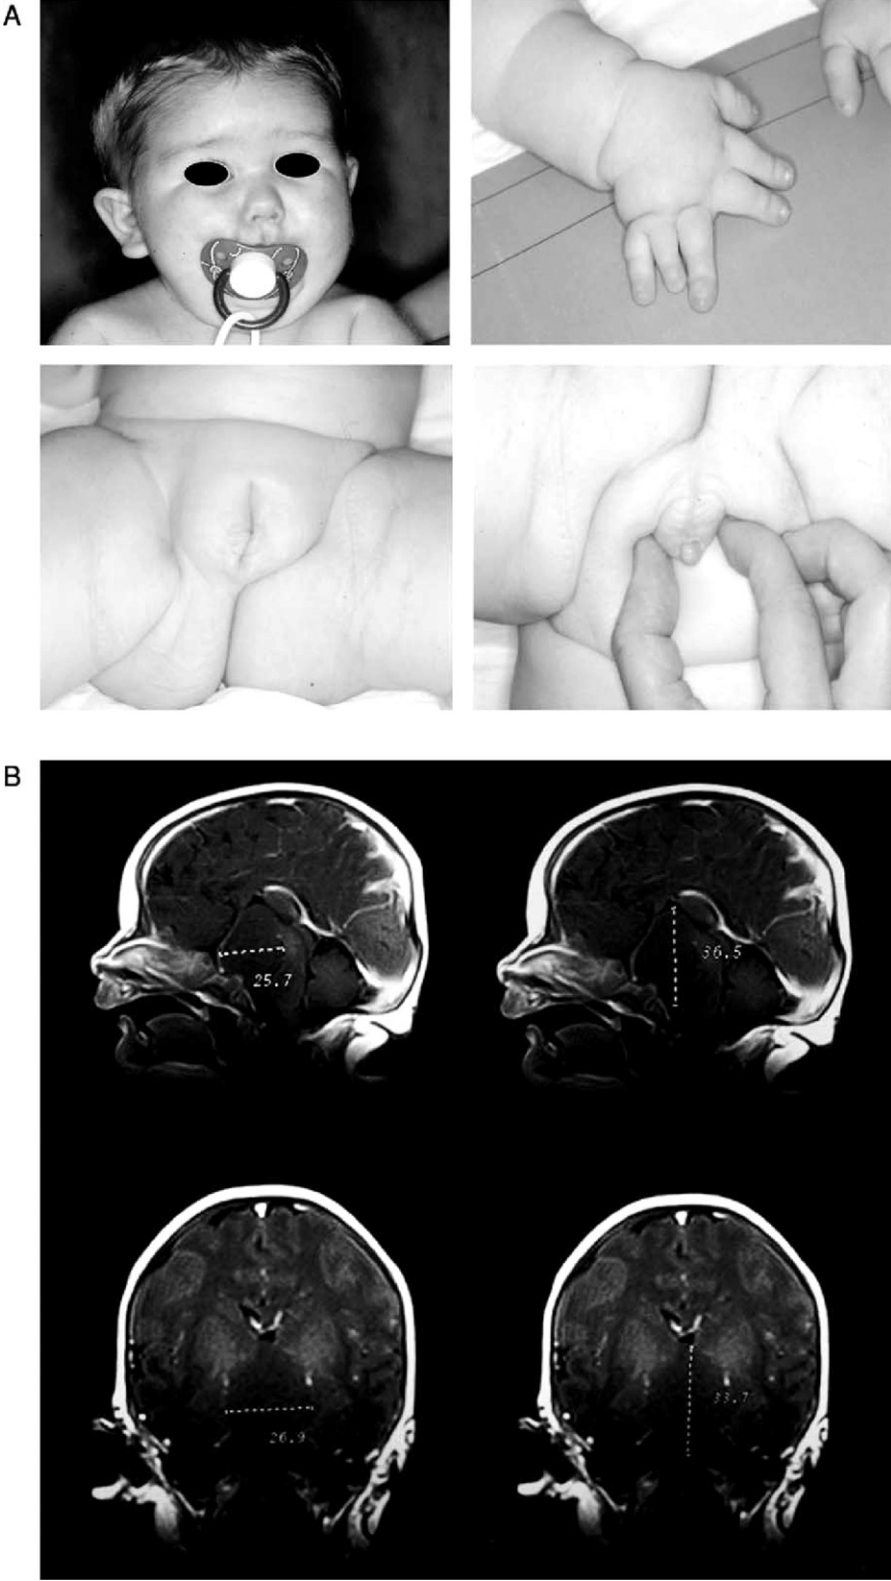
(A) Frontal view showing a phenotype suggestive of congenital hypopituitarism. Note the hands with polydactyly; micropenis and cryptorchidism are associated with panhypopituitarism. (B) Sagittal and coronal T1-weighted MR images demonstrating the mass (dotted lines) compatible with hamartoblastoma and the absence of pituitary tissue.
